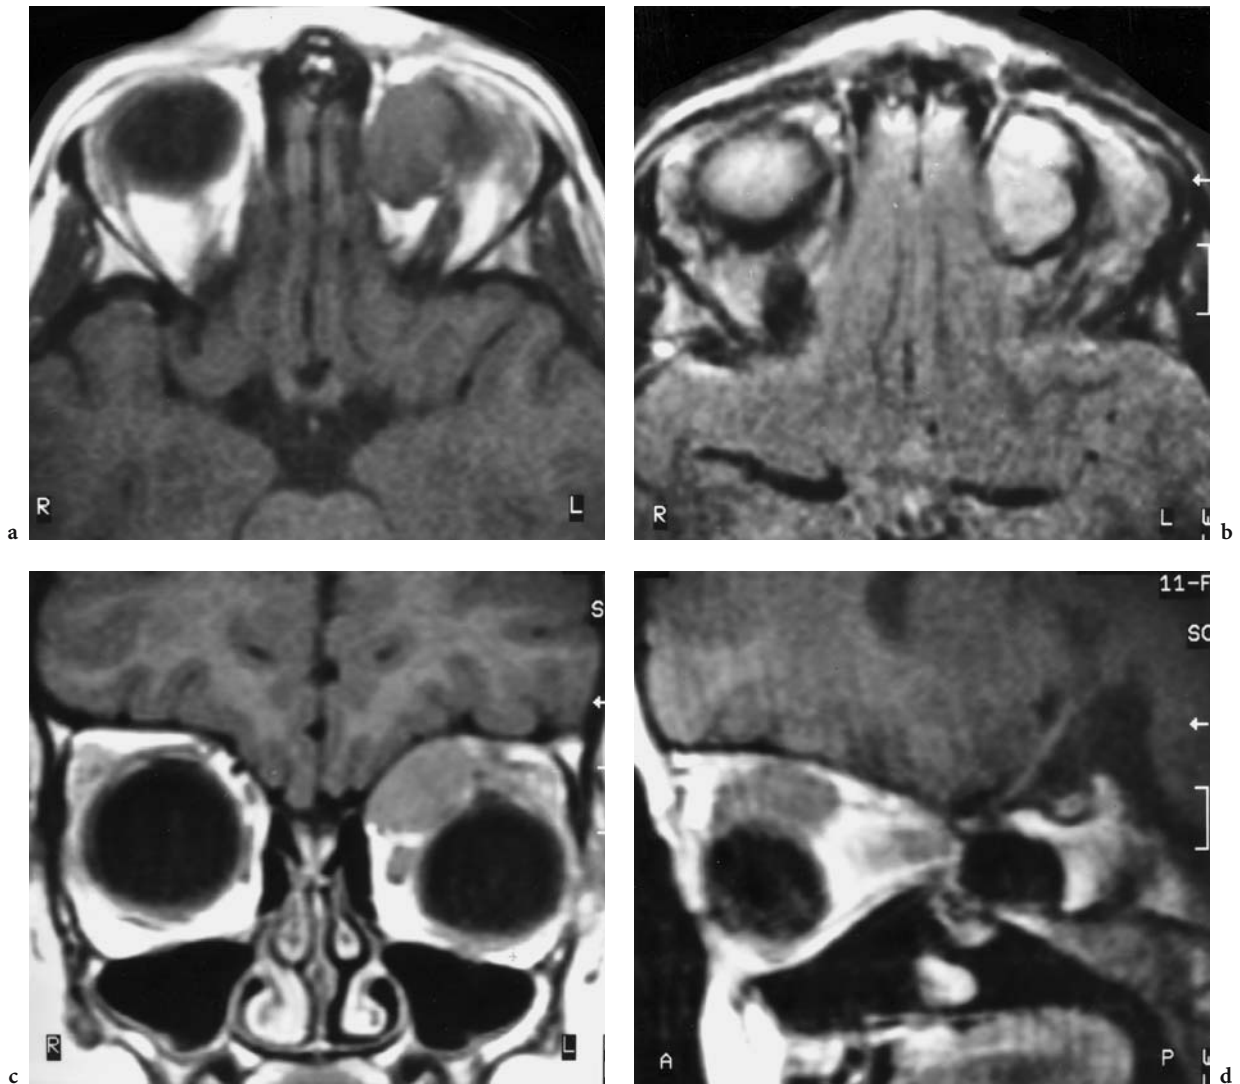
A 6-year-old girl with rapidly progressing, painless, unilateral, extra-axial proptosis of the left eye. Diagnosis: rhabdomyosarcoma. Triplanar MRI: a axial T1-weighted native view with slightly hyperintense, sharply defined lesion in the medial superior quadrant. b Corresponding T2-weighted image with hyperintensity of the tumor. c Coronal, T1-weighted, contrast-enhanced view showing similar enhancement. Caudal and lateral dislocation of the globe, corresponding to the location of the tumor in the anterior region of the superior oblique muscle. d Sagittal, T1-weighted, contrast-enhanced image with superior view of the AP expansion (slightly blurred image due to the young patient's movements). (With permission of MÜLLER-FORELL and LIEB 1995b)
